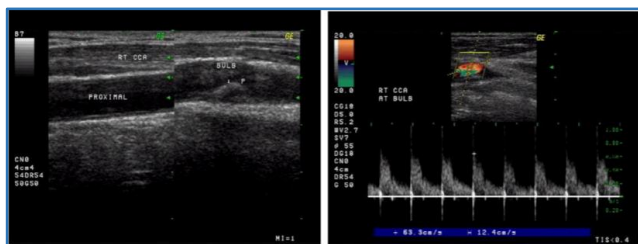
B mode and colour Doppler imaging showing moderately echogenic plaque at carotid bifurcation with luminal narrowing of <50% (case no.2)
